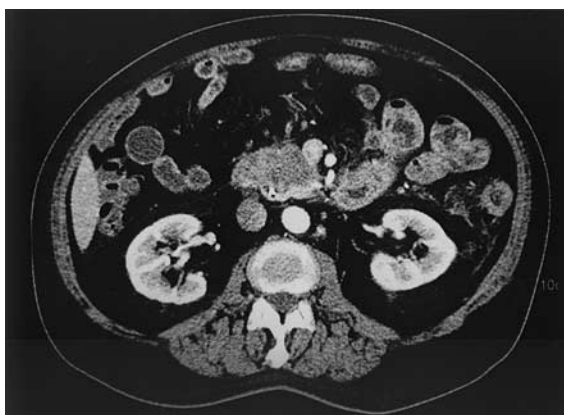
Arterial phase of multidetector CT scan, with water used as oral agent. The kidneys and aorta are contrast enhanced. A 3-cm hypodense tumor mass is seen in the pancreatic uncinate process, anterior to the aorta and inferior vena cava. The tumor abuts the right lateral aspect of the superior mesenteric vein. The superior mesenteric artery is contrast-enhanced, patent and not approached by tumor. This tumor was resected via pancreaticoduodenectomy, with negative resection margins.
